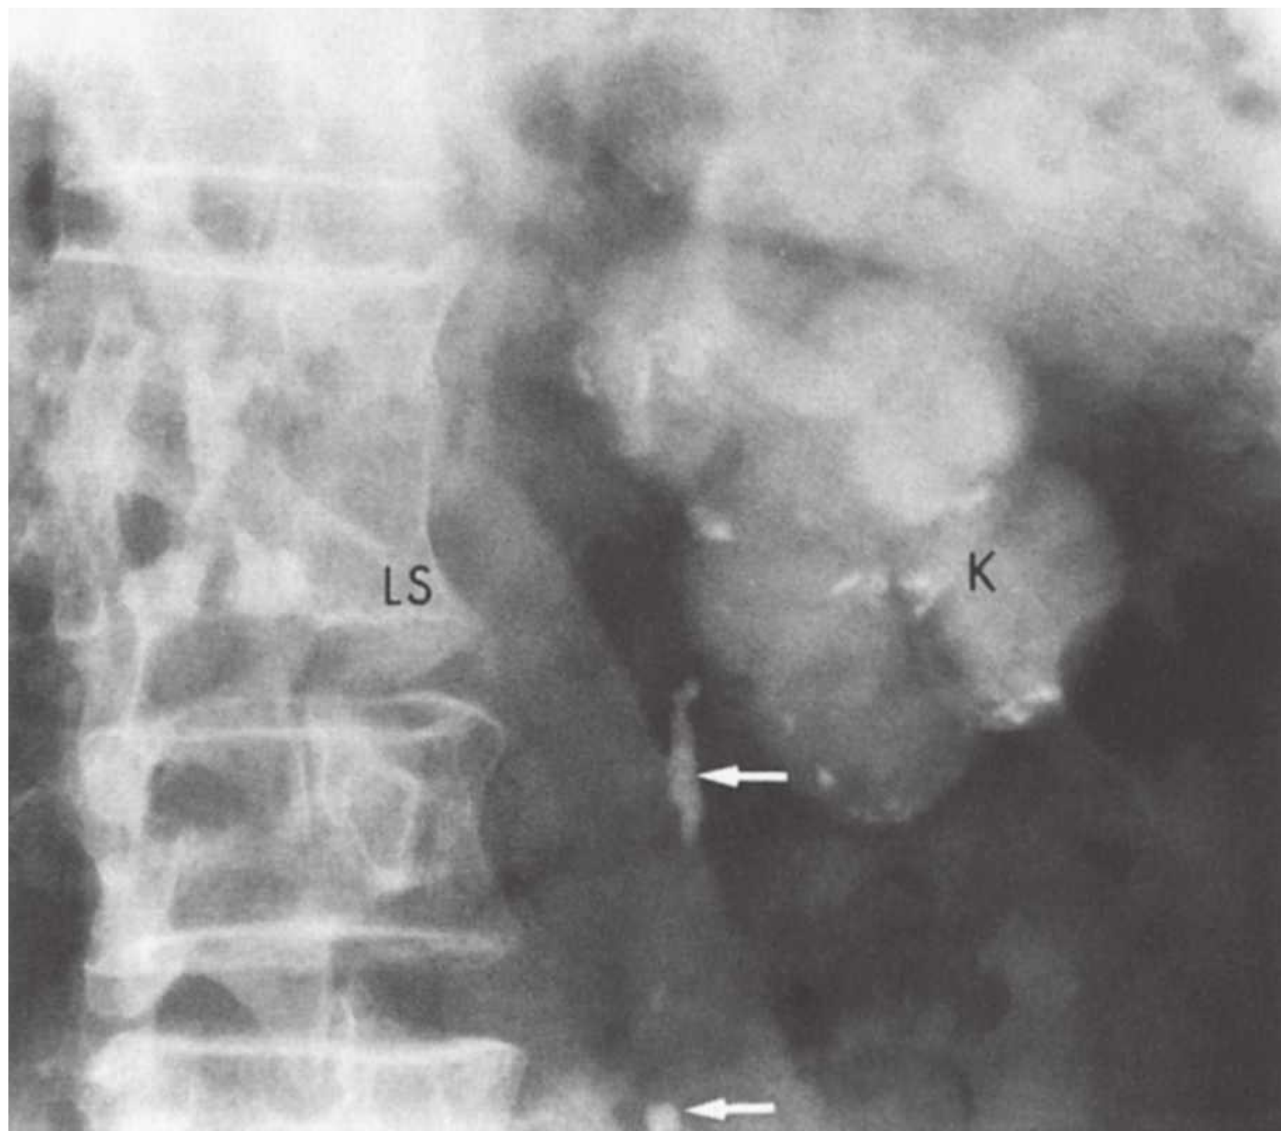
Plain film of the abdomen shows a left autonephrectomy with calcification of the kidney parenchyma and the left ureter (*arrows*). There is tuberculous involvement of the lumbar spine, resulting in fusion of the intervertebral disc space. *K*, kidney parenchyma; *LS*, lumbar spine.
